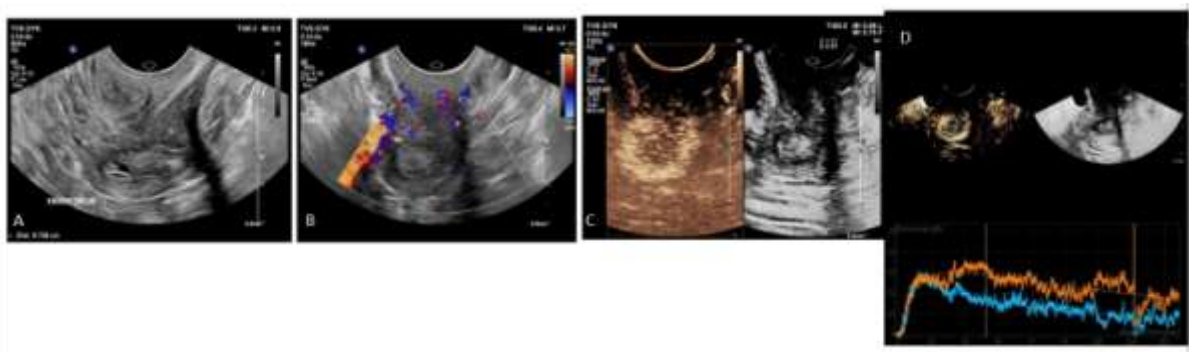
B mode (A) and color doppler (B) images of the thickened endometrium showing marked arterial enhancement and quick washout (C). TIC curves (D) red ROI in the lesion and blue ROI in the normal myometrium
